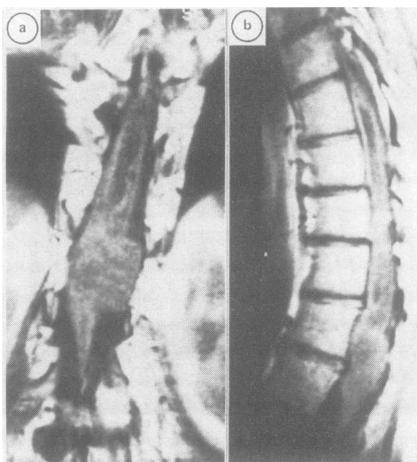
T₁ weighted MRI, coronal (a) sagittal (b), show a mass indistinguishable from the cord at the level of the conus. There is a syrinx cavity above the lesion.
